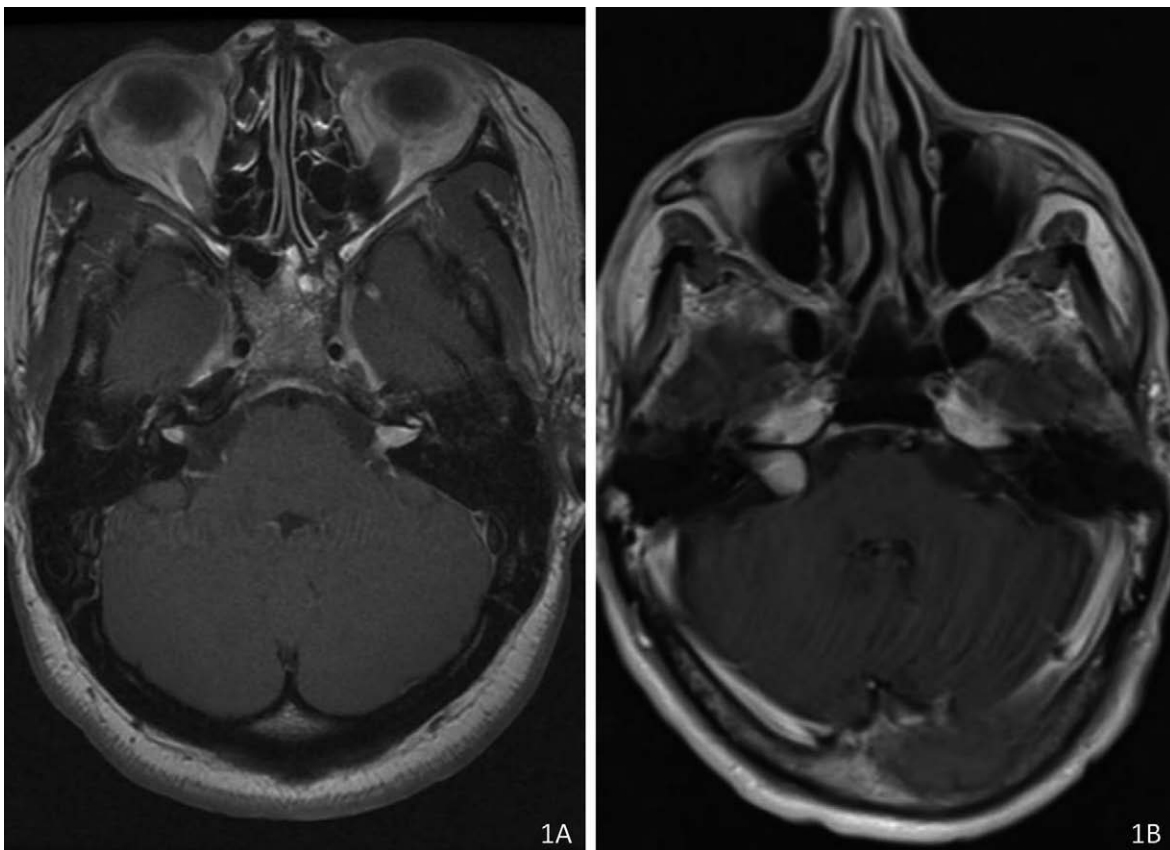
Vestibular schwannoma magnetic resonance imaging. (A) Contrast-enhanced, T1-weighted MRI demonstrating bilateral enhancing internal auditory canal lesions characteristic of patients with Neurofibromatosis type 2. (B) Contrast enhanced T1-weighted MRI demonstrating a typical medium-sized sporadic vestibular schwannoma.
